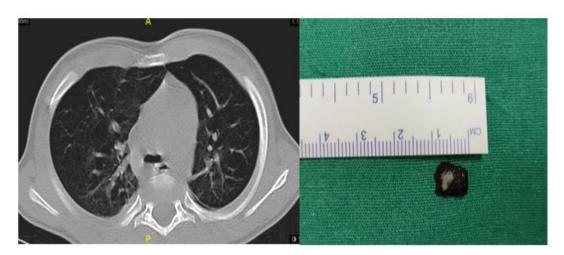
a- high-resolution CT chest of the child showing the many doubtful narrowing areas and no foreign body evidence anywhere. b- a tamarind seed foreign body that has been removed from the subglottis of the same child
